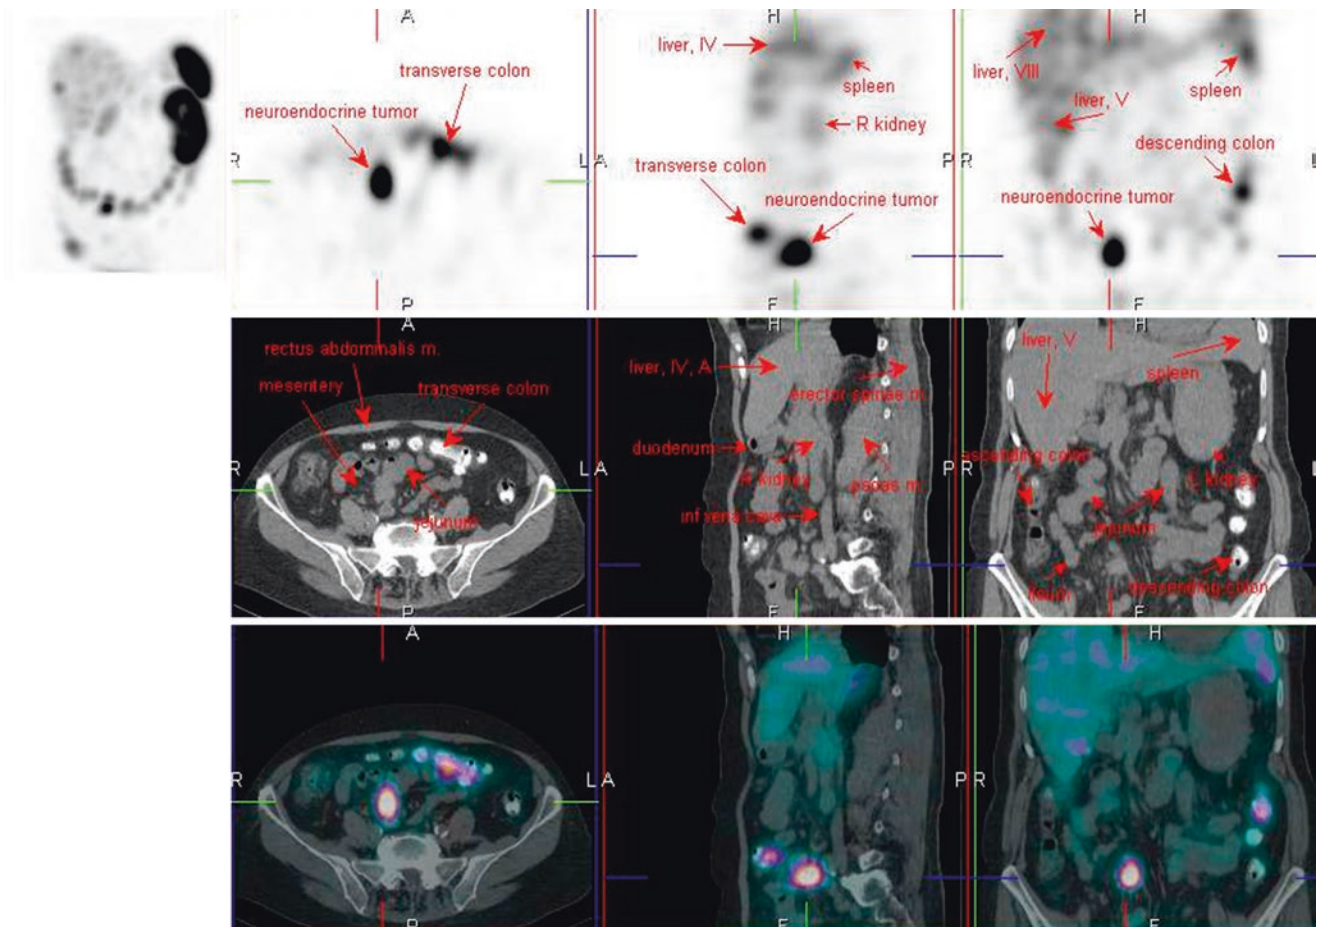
¹¹¹In-octreotide SPECT/CT
